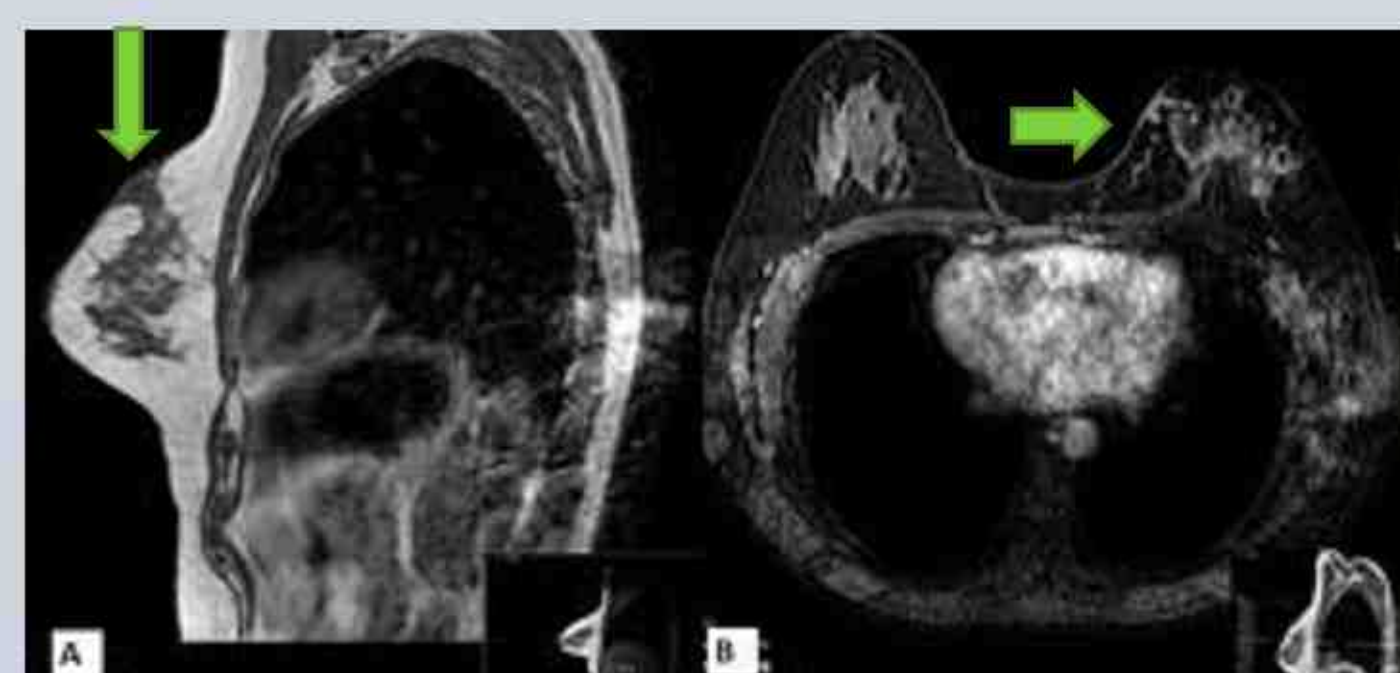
(Left) MRI of granulomatous mastitis A) sagittal T1 and B) contrast axial T1 subtraction. A) shows sinus tract formation to the skin superiorly within the left breast. B) shows multiple ring enhancing lesion in the left breast.
